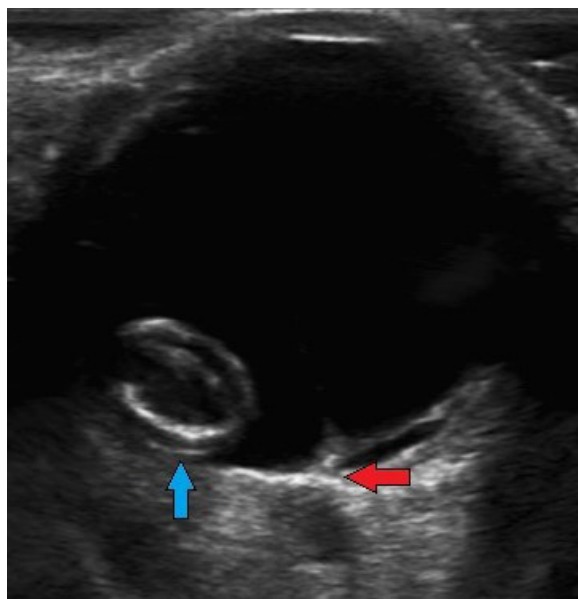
B scan ultrasonography of right eye reveals retinal detachment (red arrow). Also note the presence of dislocated intraocular lens noted in dependent part of posterior segment (blue arrow)
